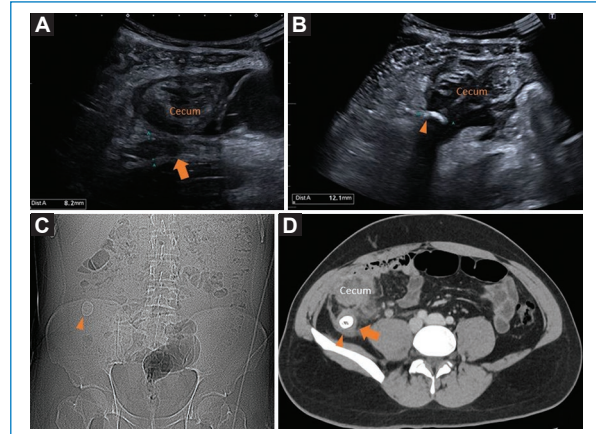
A 25-year-old male with abdominal pain in the right iliac fossa of one week's evolution. Nausea without vomiting. Afebrile. Positive Murphy sign on examination, without signs of peritoneal irritation. C-reactive protein 1.88, leukocytes 14,000. Ultrasound is requested to rule out biliary involvement. A and B: ultrasound where significant parietal thickening of cecum and terminal ileum is visualized, with a 15 mm hyperechoic image with acoustic shadow adjacent to the cecum suggesting appendicolith (arrowhead) in a possible thickened appendix difficult to approach (arrow). C and D: the study is completed with computed tomography, where a thickened cecal appendix is confirmed (diameter greater than 26 mm, arrow) in retrocecal location, with a bulky 18 mm appendicolith in the middle third of the appendix (arrowhead), visible on scout image (C).
